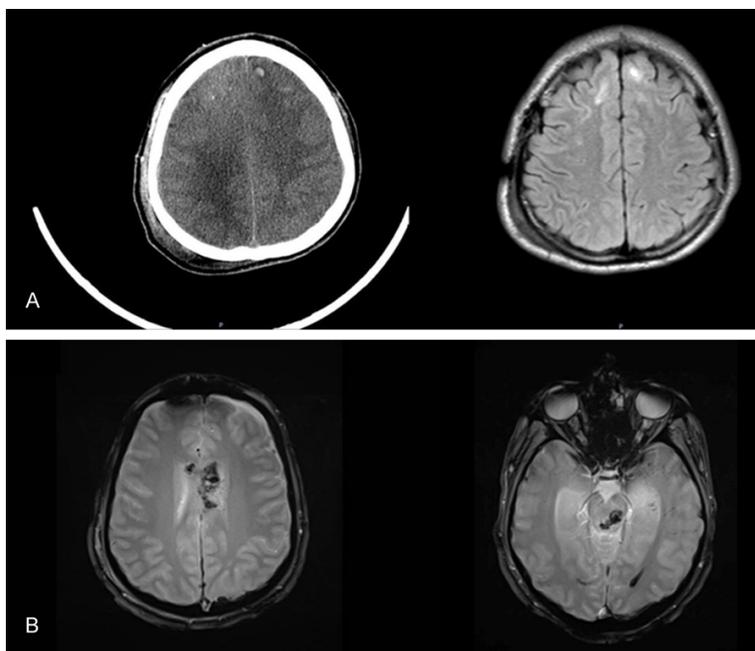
A: CT and MRI showed diffused axonal injury with hemorrhagic contusions at the grey-white matter junction. B: Gradient echo MRI showing the effect of hemosiderin deposition in the corpus callosum and midbrain (Adams grade 3).
